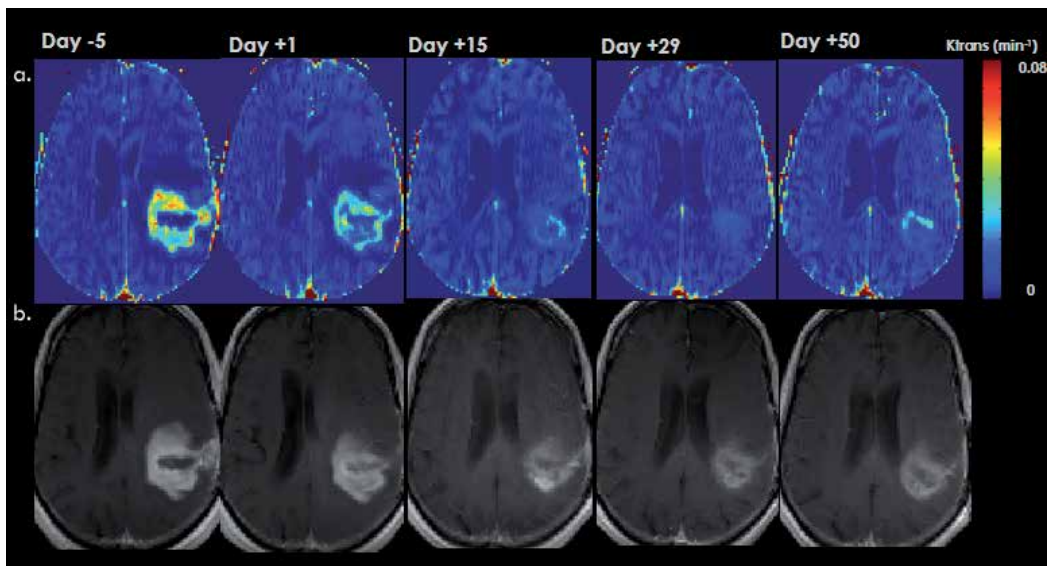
(a) Maps of K^{trans} , a measure of blood-brain barrier permeability. (b) T1-weighted anatomic images after intravenous administration of a contrast agent (gadolinium-DTPA), demonstrating a region of bright signal corresponding to the recurrent brain tumor in the left frontal lobe. Note the reduction in K^{trans} following Gd-DTPA injection and kinetic analysis, and the accompanying shrinkage of the mass after injection of Cediranib (VEGF inhibitor). Figure from Jennings et. al. (unpublished data).
